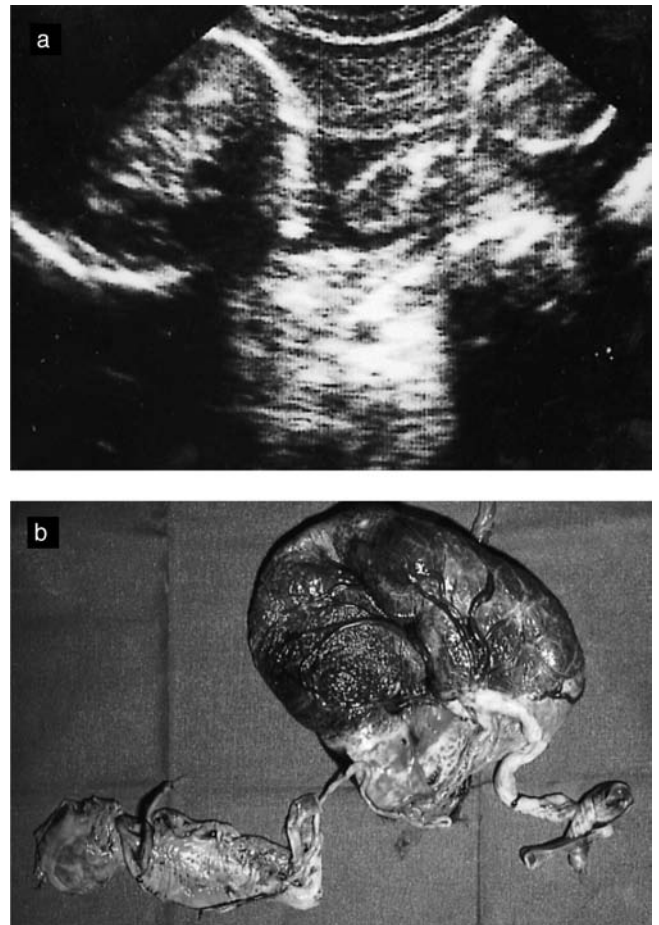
Situation after selective fetocide. (a) Sonogram shows the small dead fetus in the upper right corner of the picture. (b) After delivery the 'fetus papyraceus' and the 'dead part' of the placenta can easily be seen.
